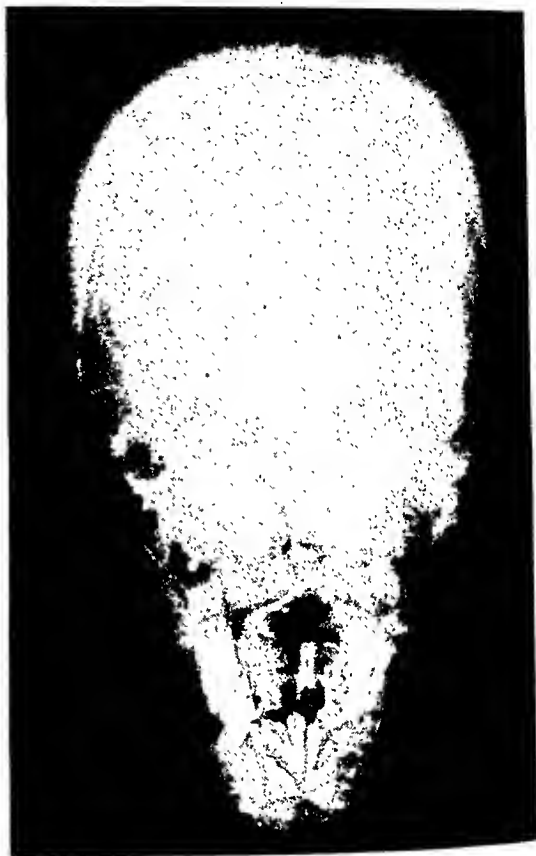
Skull roentgenogram showing vertical striations, giving the appearance of hair standing on end.
